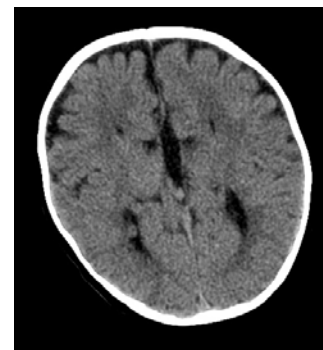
Axial view of noncontrast CT of brain demonstrates parallel appearance to the lateral ventricles.
